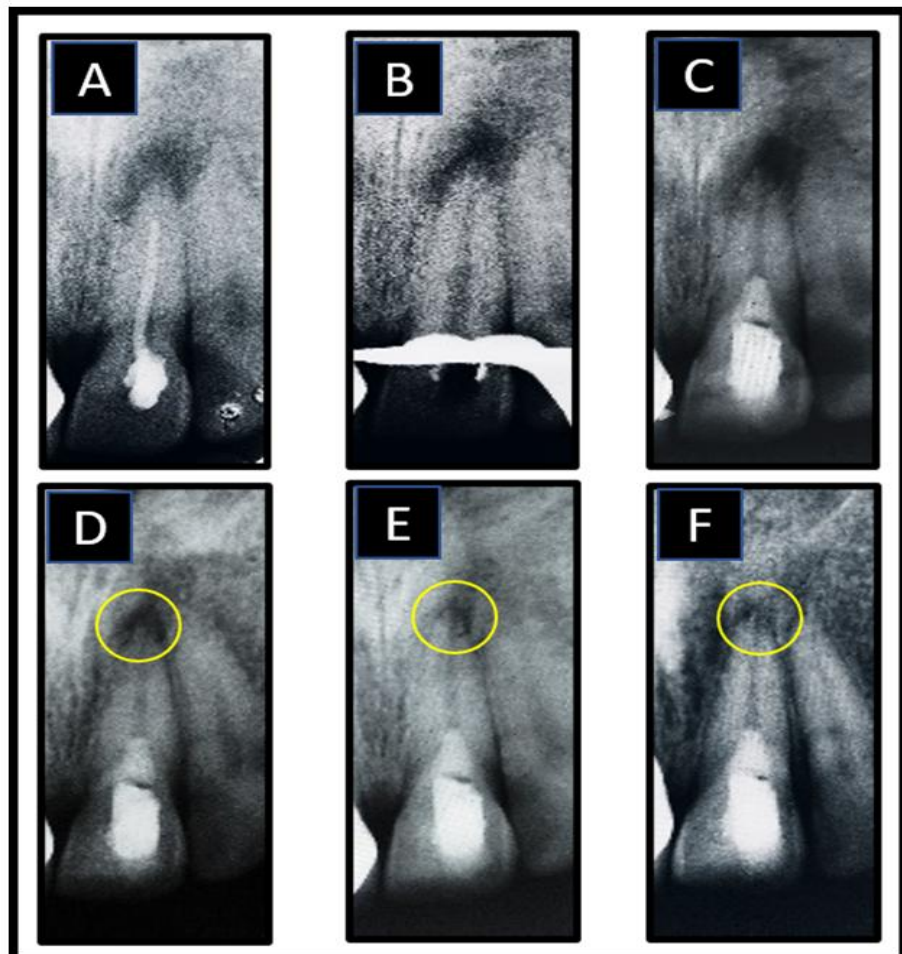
A. Poorly cleaned, shaped and obturated 11 with periapical radiolucency B. GP removed C. Immediate post-op. D, E & F. 6, 9 and 12 months follow up respectively, showing reduction in peri-apical radiolucency
